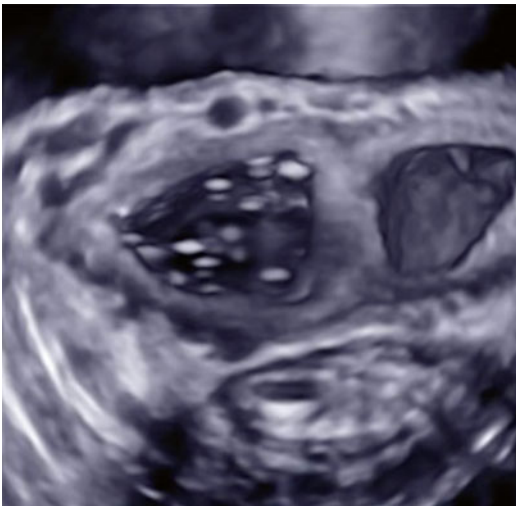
Transverse 3D rendered image of the vagina after instilling ultrasound gel in both hemivagina. ESHRE/ESGE V1: longitudinal non obstructing vaginal septum
